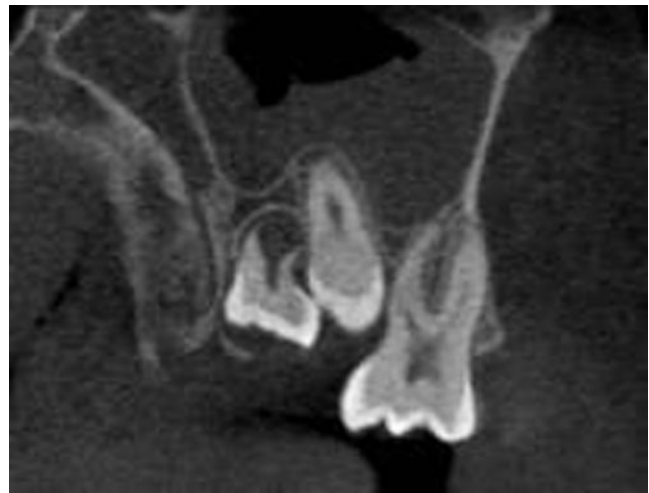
Sagittal CBCT section through the unerupted UR7
